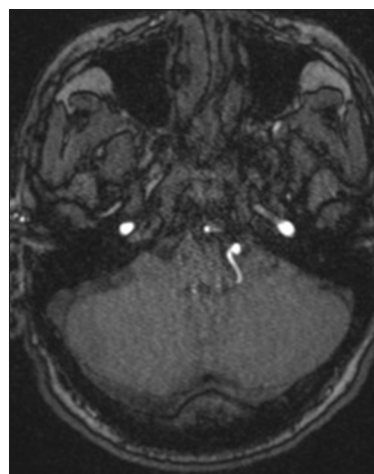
Preoperative axial time of flight magnetic resonance imaging: Origin of left tortuous posterior inferior cerebellar artery from vertebral artery.
